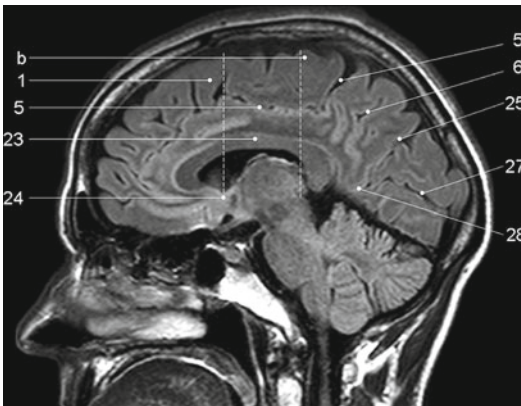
Sagittal FLAIR image at the midline. 1 superior frontal gyrus, 5 “pars bracket”, cingulate sulcus, 6 precuneus, parietal lobe, 23 body of the corpus callosum, 24 anterior commissure, 25 parietooccipital sulcus, 27 calcarine fissure, *b* paracentral lobule, 28 cuneal point
